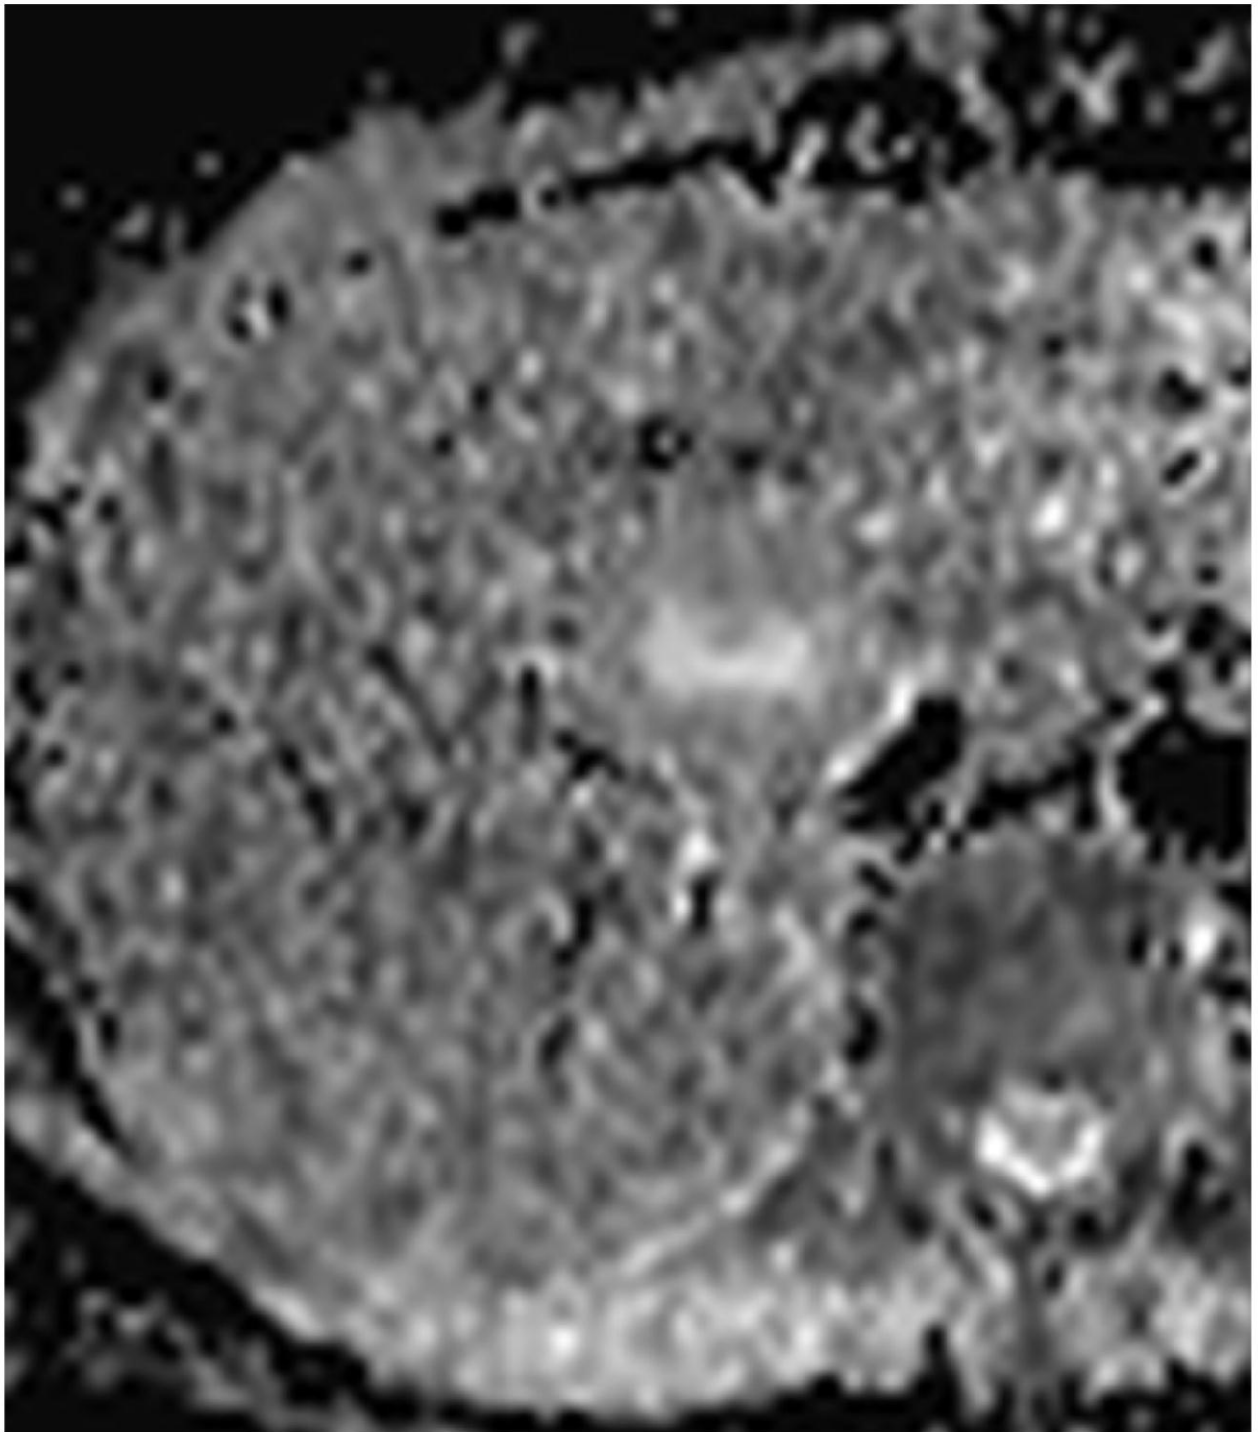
Diffusion-weighted MRI, ADC map. FNH shows isointensive signal with hyperintense central scar.
